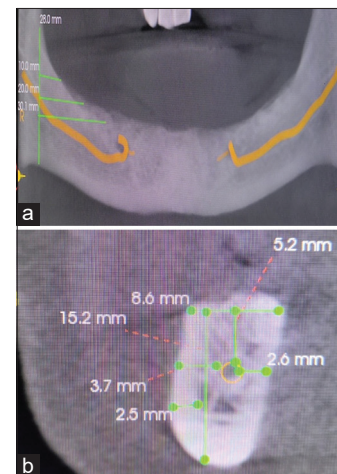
(a) CBCT showing IAC and distance from the retromolar pad; (b) Measurements from the Inferior alveolar canal
